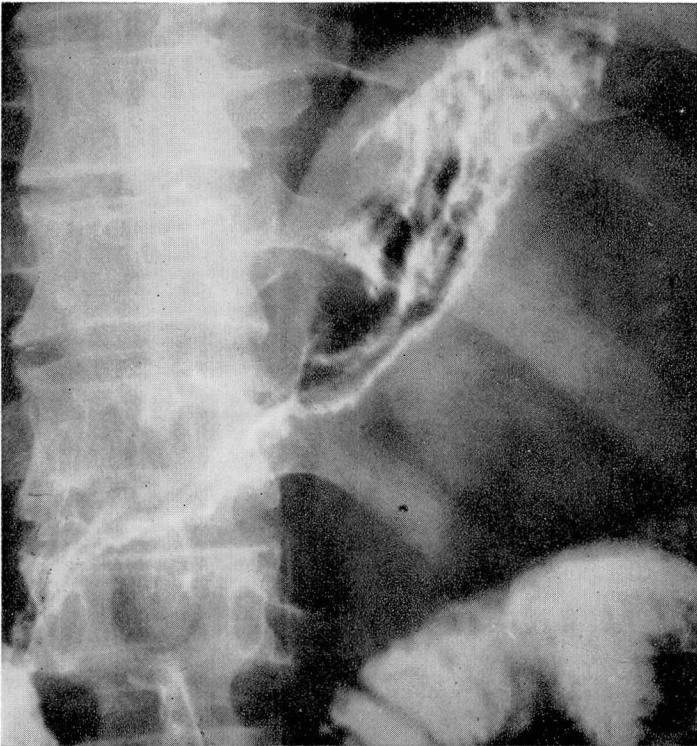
Postoperative appearance of stomach by roentgenogram. About three fifths of the stomach was resected; continuity was re-established by a Billroth I anastomosis.
